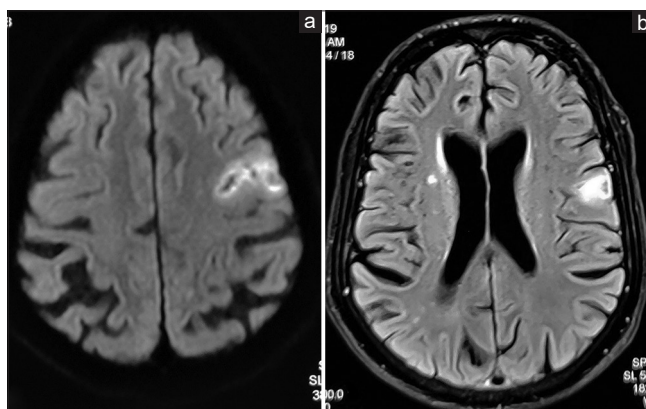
MRI brain (a) diffusion-weighted sequence showing diffusion restriction in the left anterior operculum. (b) FLAIR sequence showing additional right frontal subcortical subacute infarct
